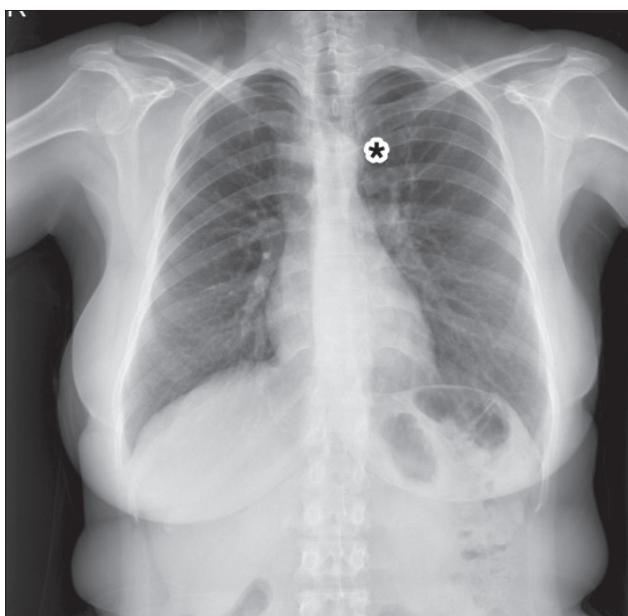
Chest radiograph, asterisk shows the indistinct shadow of the aortic knob.
